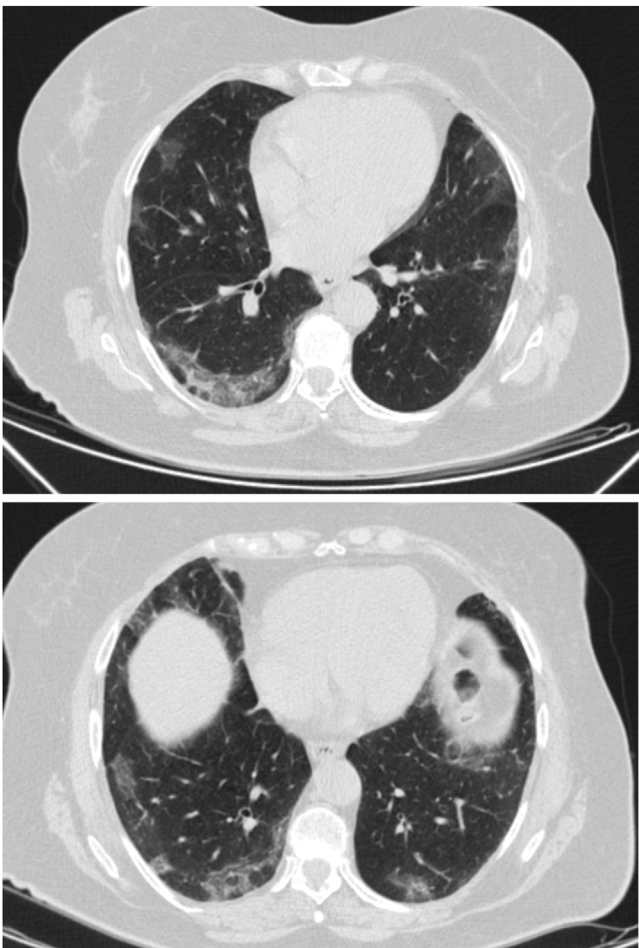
Chest CT images showing bilateral ground glass opacities.
